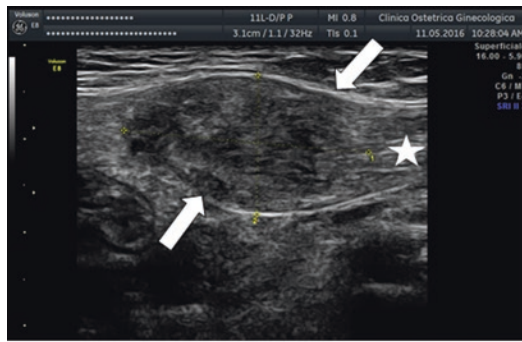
The ultrasonographic appearance of a *rectus abdominis endometriosis* (straight arrows) in a 30-year-old woman with one previous cesarean section 4 years before. The muscular layer (star)
